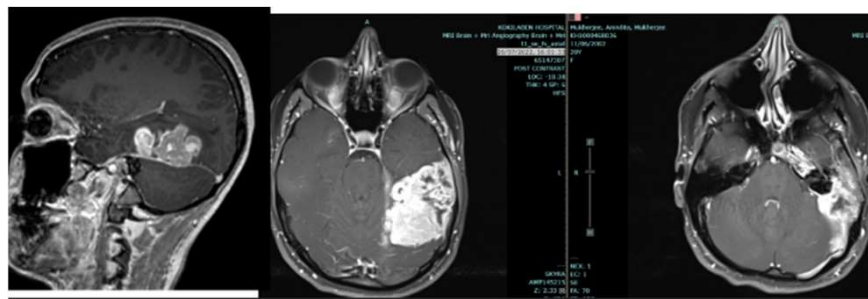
MRI Brain a) sagittal section b) axial section showing left temporal lesion.
